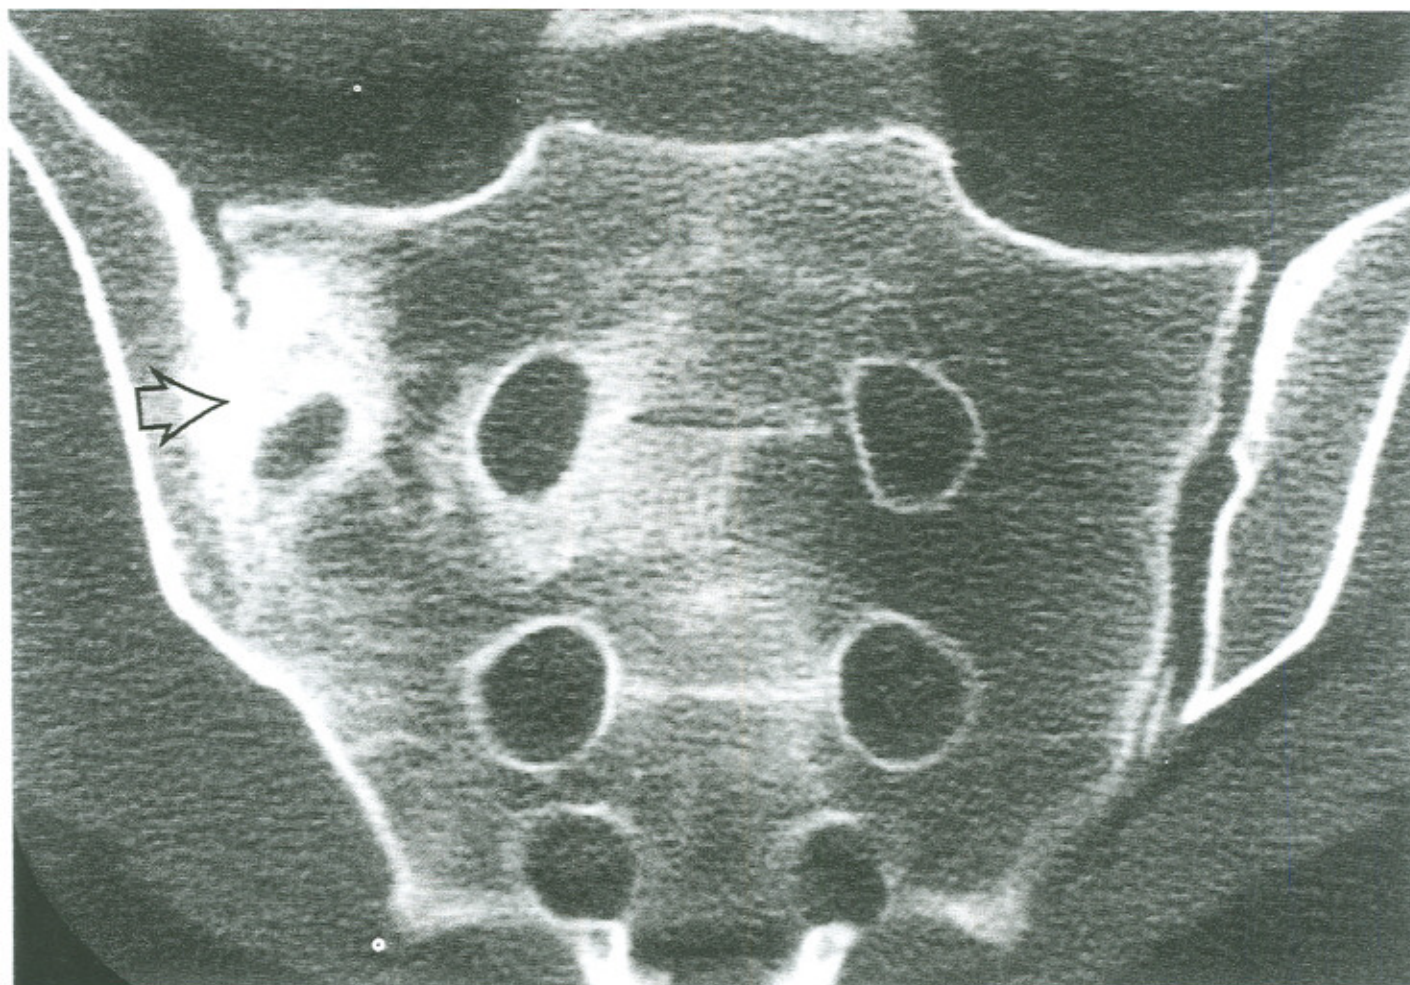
Computed tomography (CT) image of the sacroiliac (SI) joints of patient in case one. The left SI joint (arrow) shows partial fusion, an attempt at bony repair secondary to long standing infection.
